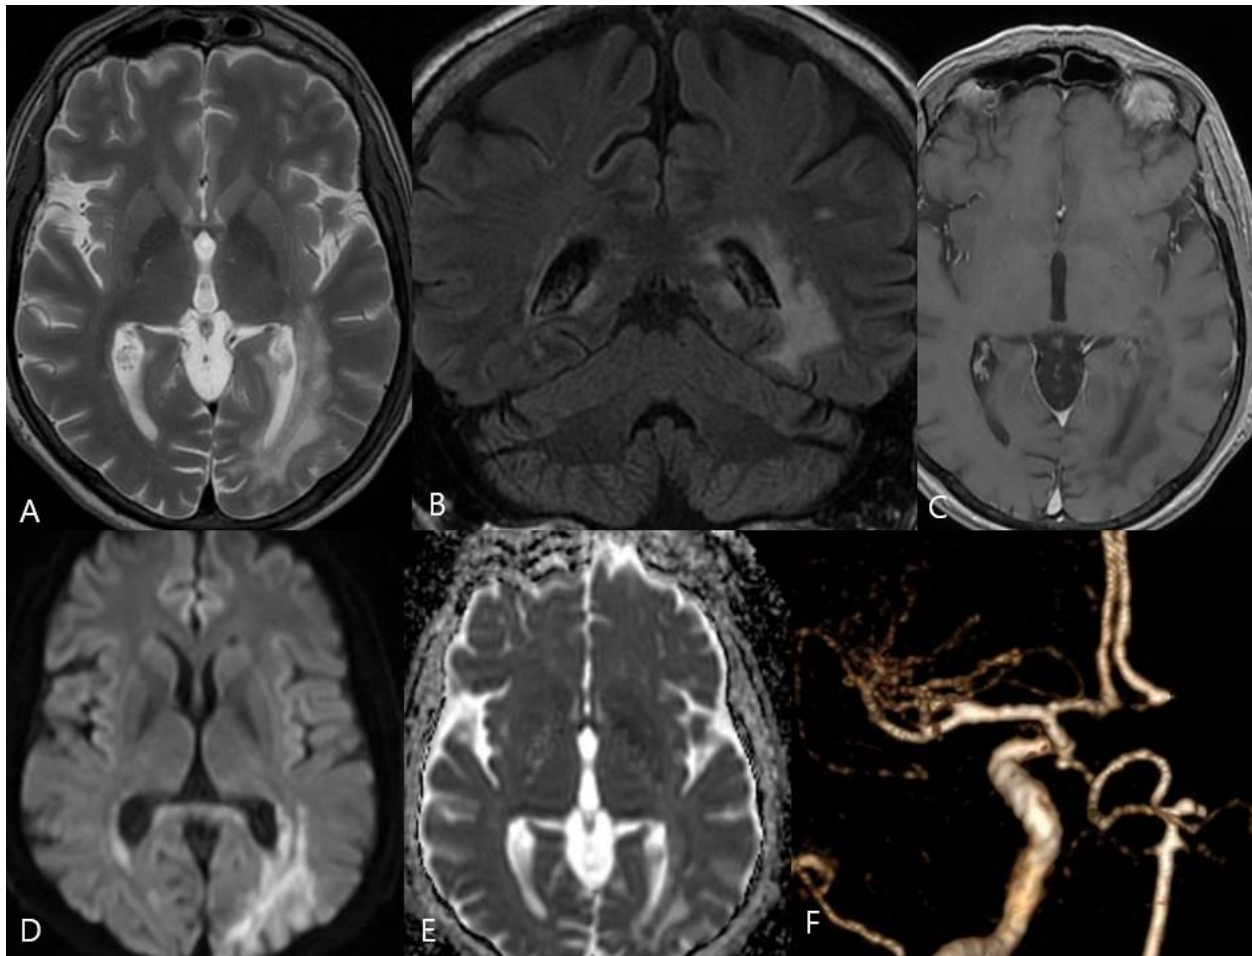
Brain MRI on the rehospitalised day. High - intensity signals on fluid - attenuated inversion recovery (FLAIR) image and diffusion - weighted image with elevated apparent diffusion coefficient in the territory of the left internal carotid artery, indicating vasogenic oedema.
